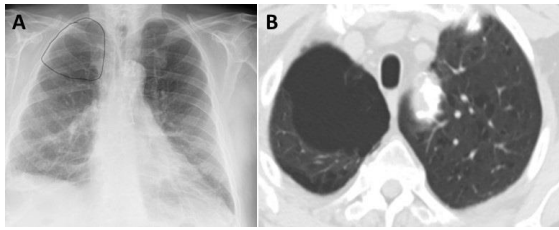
Panel A: Chest x-ray showing right lung bullae (circled). Panel B: Confirmation of enlarging bulla on CT scan. To view Figure 2 in a separate, enlarged window click [here](#).
